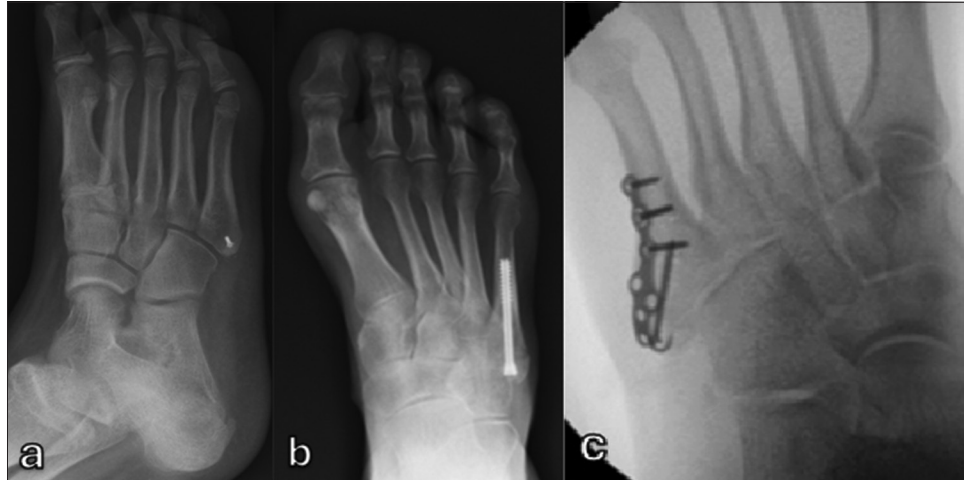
Radiographs showing fixation methods for tuberosity avulsion fracture. (a) Fragment excision and re-attachment of peroneus brevis tendon using bone anchor. (b) Intramedullary screw fixation. (c) Fixation with hook plate.
